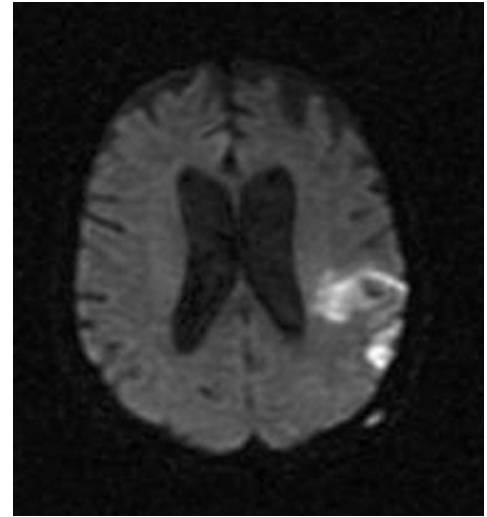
MR brain scan in the acute stage of cerebral ischaemia (DWI sequence). Left middle cerebral artery infarct showing ischaemic lesions in the cortex and subcortex as bright signal.
